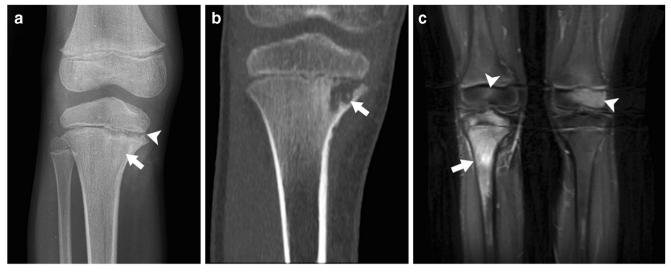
Chronic recurrent multifocal osteomyelitis in a 15-year-old boy with polyarticular pain that is more prominent in the right knee. a Anteroposterior radiograph of the right knee shows widening and irregularity of the medial aspect of the proximal tibial physis (*arrowhead*) and an ill-defined lesion in the adjacent metaphysis (*arrow*). b Coronal reformatted CT image of the right proximal tibia
